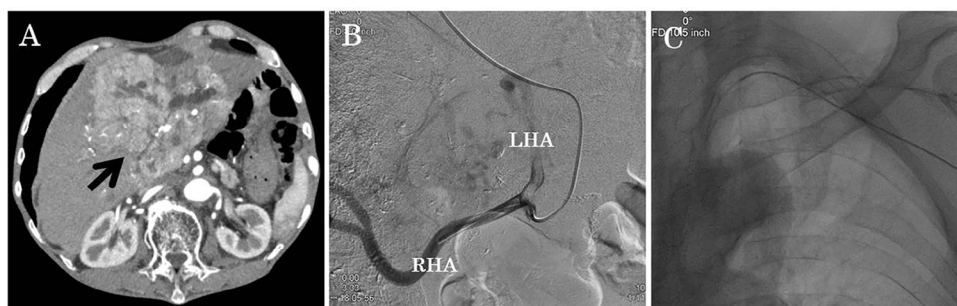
A) Abdominal contrast computed tomography demonstrated contrast lesion in the liver parenchyma (arrow). (B and C) Arterial infusion catheter was inserted in the right hepatic artery via left subclavian artery. Abbreviations: LHA, left hepatic artery; RHA, right hepatic artery.
